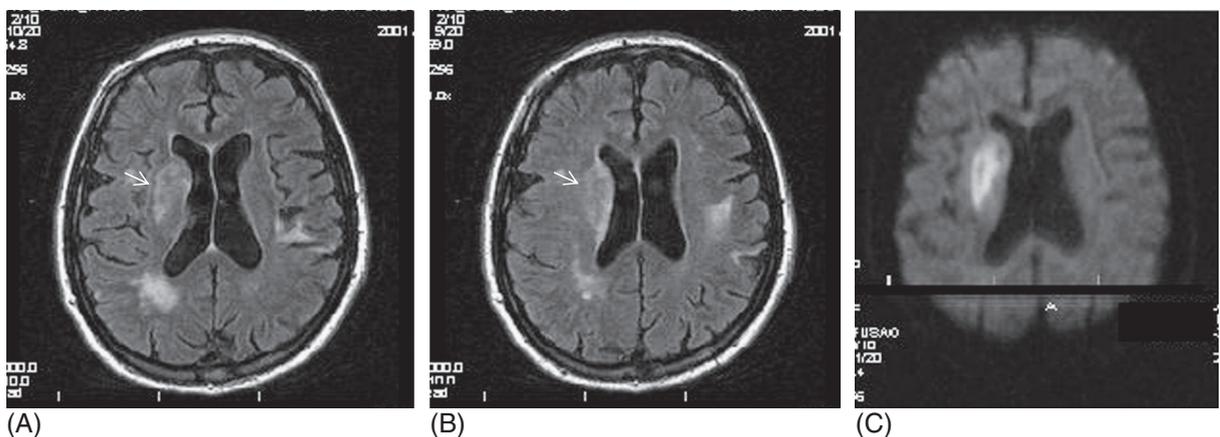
T2 (A, B) and diffusion-weighted (C) MRI sequences showing a “comma shaped” infarct involving the territory of the lenticulostriated arteries (arrows).
